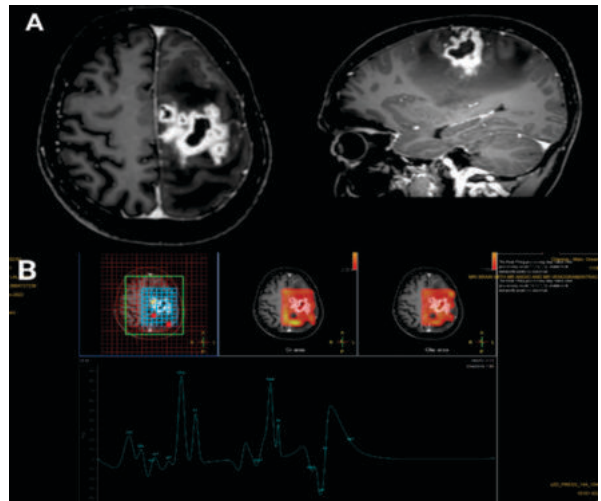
Contrast enhanced MRI brain showing conglomerated peripherally enhancing altered signal lesions in the left high frontoparietal lobe with associated significant mass effect(A), and choline and NAA (N-acetyl aspartate) spike (B)
